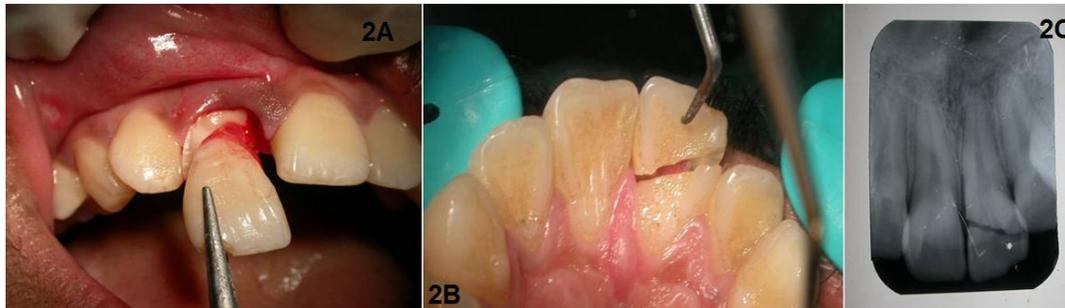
2. A) Preoperative labial view, B) Preoperative palatal view, C) Preoperative radiograph
